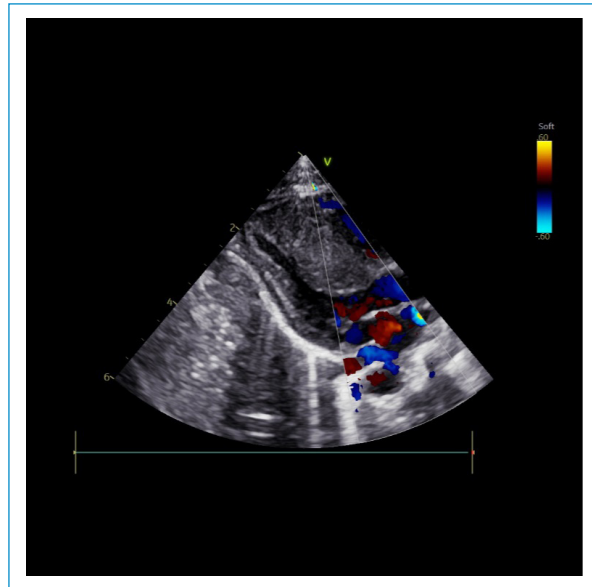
Parasternal long axis view.
